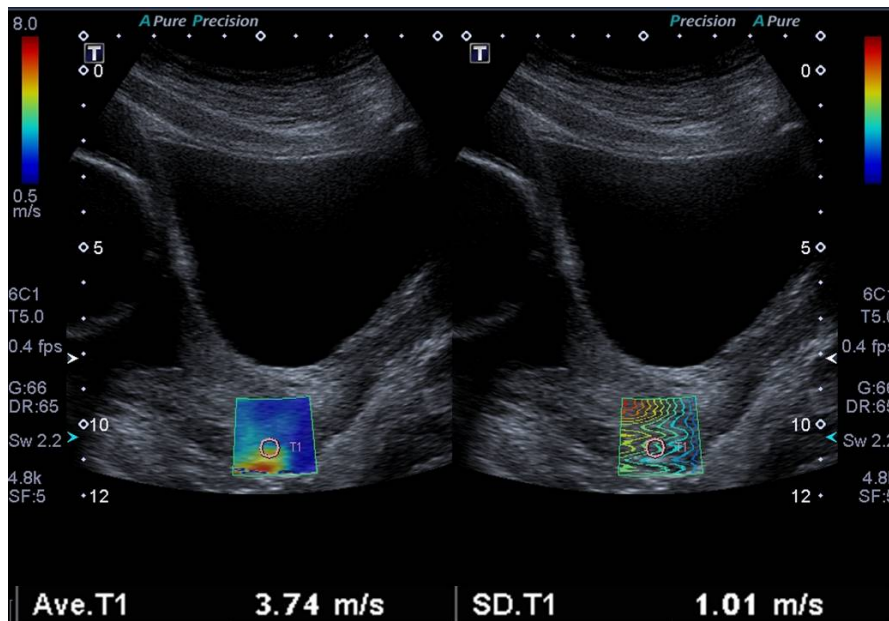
Example of loss of shear wave propagation in the posterior portion of the external os using the transabdominal ultrasound approach, demonstrating a non-uniform elastogram and erratic propagation lines at a depth greater than 10cm and high SD of 1.01m/s.
